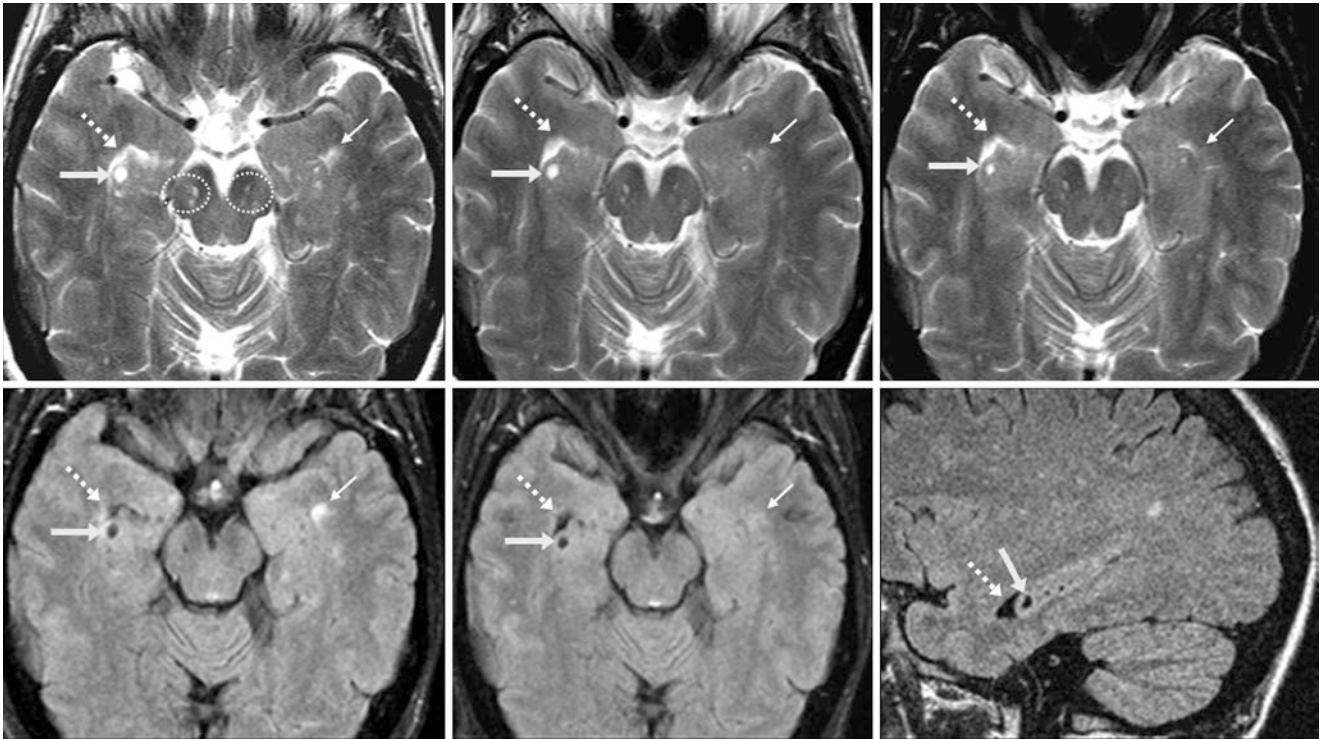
A 47 year old underwent a 1.5 T MRI. A T2WI (*top left*) depicts a single prominent right hippocampal cyst (*arrows*), with other smaller cysts medial to the temporal horn (*dashed arrows*) as well as dilated PVSs within the cerebral peduncles (*dotted circles*). The cysts and PVSs were unchanged from MRIs both 3 years (*top middle*) and 6
